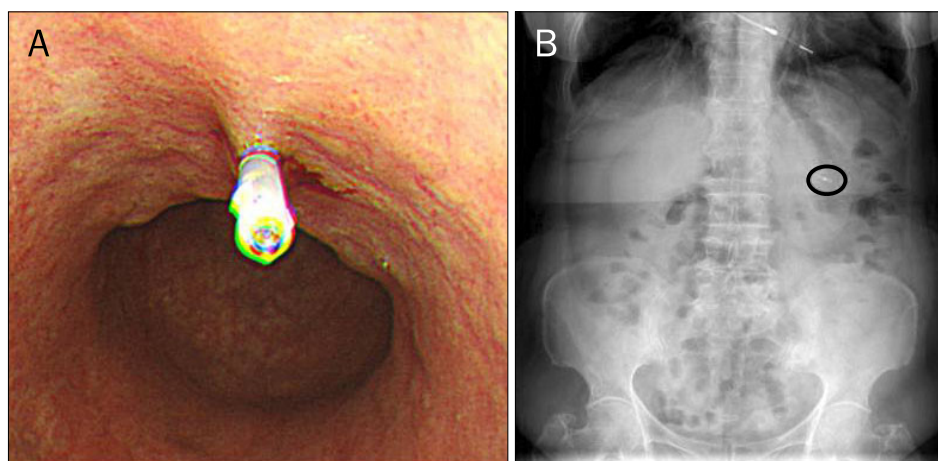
Pre-operative endoscopic clipping for early gastric cancer (HX-600-090L[®]; Olympus). Pre-operative application of a clip at the proximal side of the lesion (A) and plain abdominal x-rays obtained after clipping in the upright position (circle; B).
